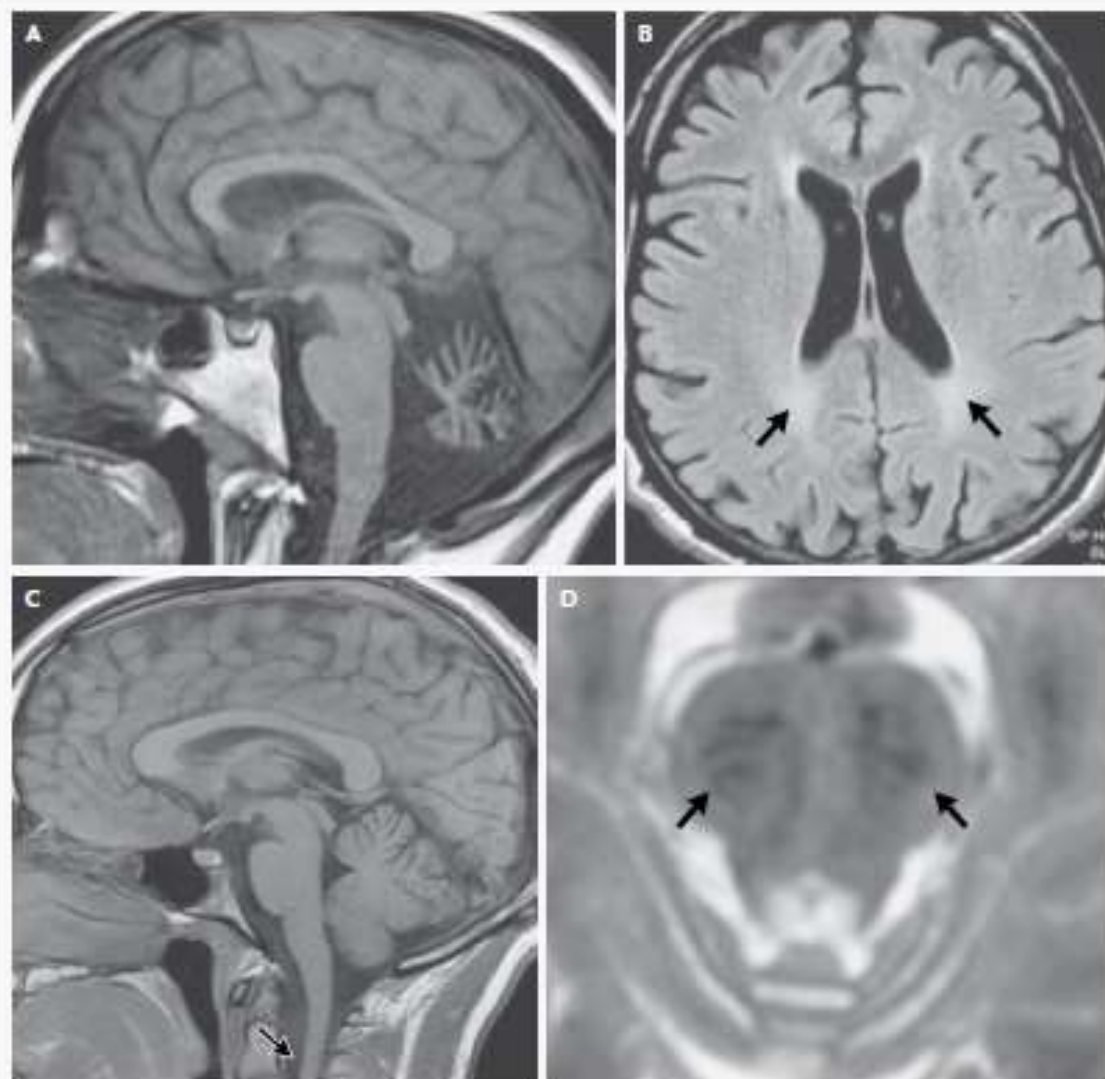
MRI Scans Showing Four Types of Autosomal Recessive Cerebellar Ataxias.
